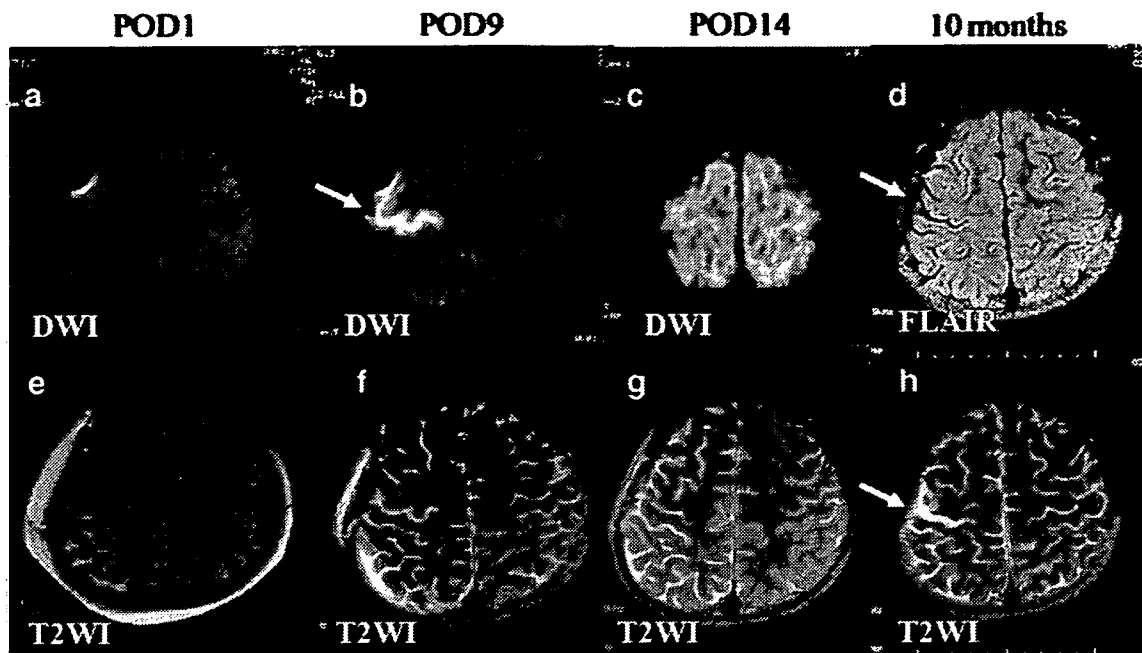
Case 6. MR imaging 1 day (a, e), 9 days (b, f), 14 days (c, g), and 10 months (d, h) after right STA–MCA anastomosis. Linear high signal intensity sign by DWI transiently appeared at pre-central gyrus
